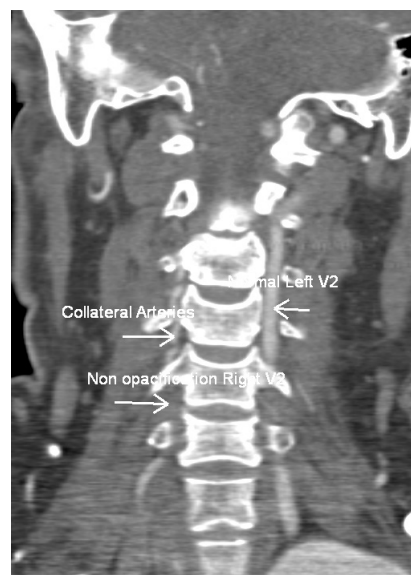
Coronal images of CT Angiogram neck. Long segment non-opacification of proximal right vertebral artery involving V2 segment with presence of multiple collateral arteries suggestive of chronic thrombosis. Normal opacification of left vertebral artery.
